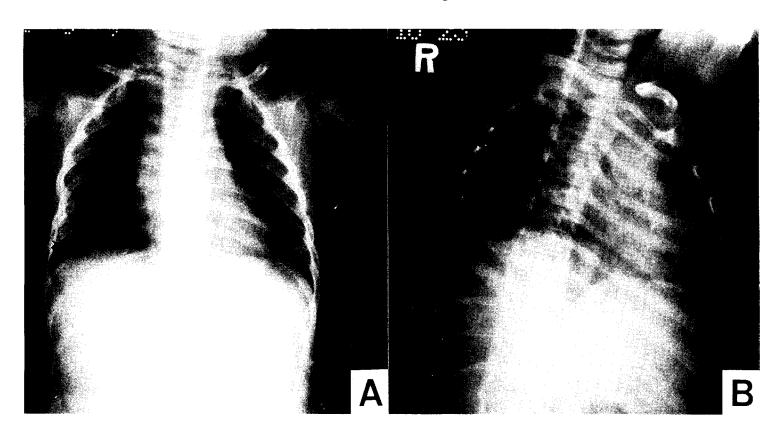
Chest X-ray: PA view(A) and rib cage view(B) shows rib involvement at the right 6th, 7th, and left 6th(arrows). The involved ribs show fusiform enlargement with internal low density and minimal marginal sclerosis. There was no lung parenchymal lesion detectable on plain film.
